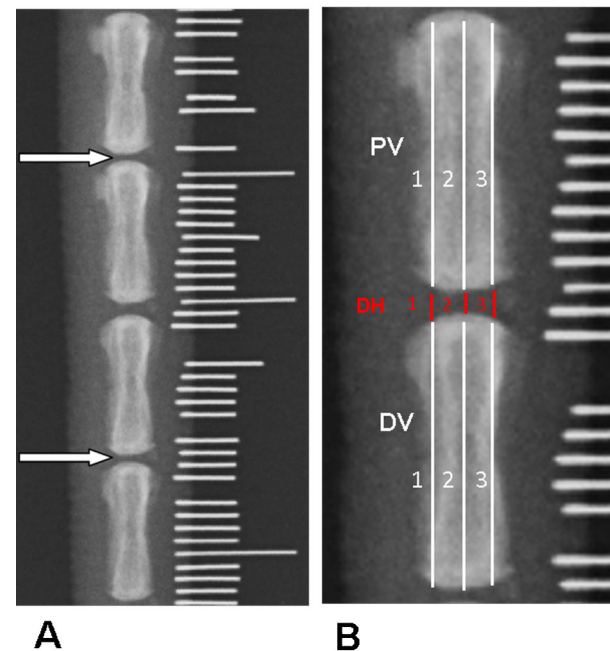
Radiographic assessment of intervertebral disc degeneration. *A*, Radiographic images were taken using a radiopaque scale with millimeter markings to recognize the intervertebral disc level of interest. Arrows indicate punctured intervertebral discs. *B*, Using digitized radiographs, measurements including the proximal (PV) and distal (DV) vertebral body height and intervertebral disc height (DH) were analyzed using the public domain image analysis program developed by the U.S. National Institutes of Health - ImageJ (<http://imagej.nih.gov/ij/>). 1 = anterior; 2 = middle; 3 = posterior.
